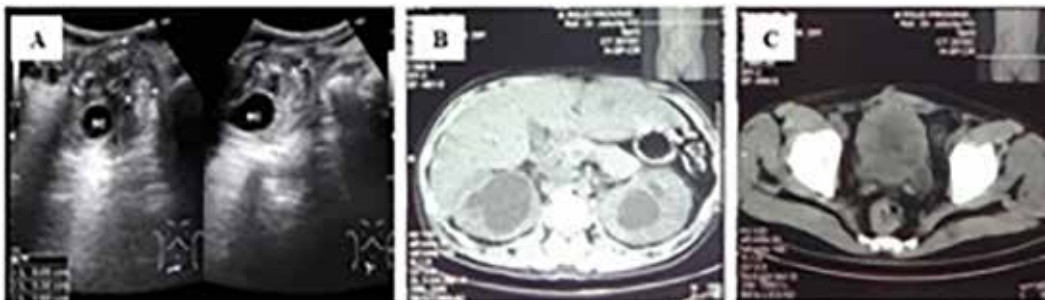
A. Urological ultrasonography concluded the patient had bilateral hydronephrosis, and clot retention with a differential diagnosis of a mass. B. Abdominal CT scan without contrast showed bilateral hydronephrosis. C. Lobulated thickness on the right, left and posterior bladder wall, expansion of the lesions to the intestines, and surrounding organs.
